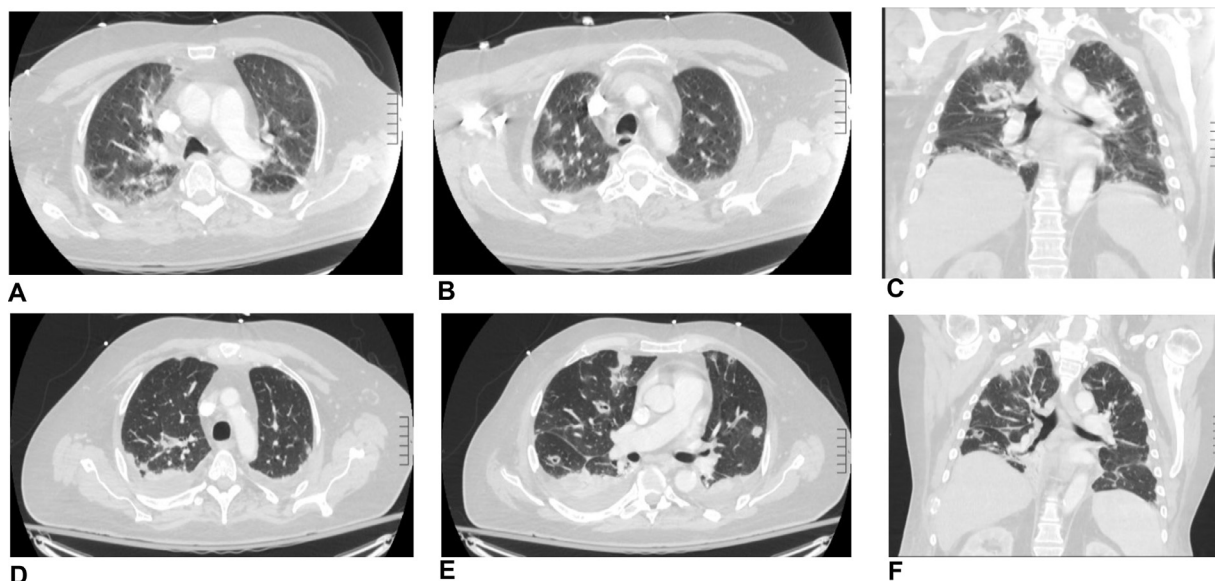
(A-C) Axial contrast-enhanced CT images of the chest obtained day of admission showing bilateral patchy opacities in the lungs concerning for atypical pneumonia. (D-F) Contrast-enhanced CT of the chest (PE protocol) showing progression of bilateral opacities with new cavitary lesions most consistent with septic emboli in the context of methicillin-sensitive *S. aureus* (MSSA) bacteremia.
